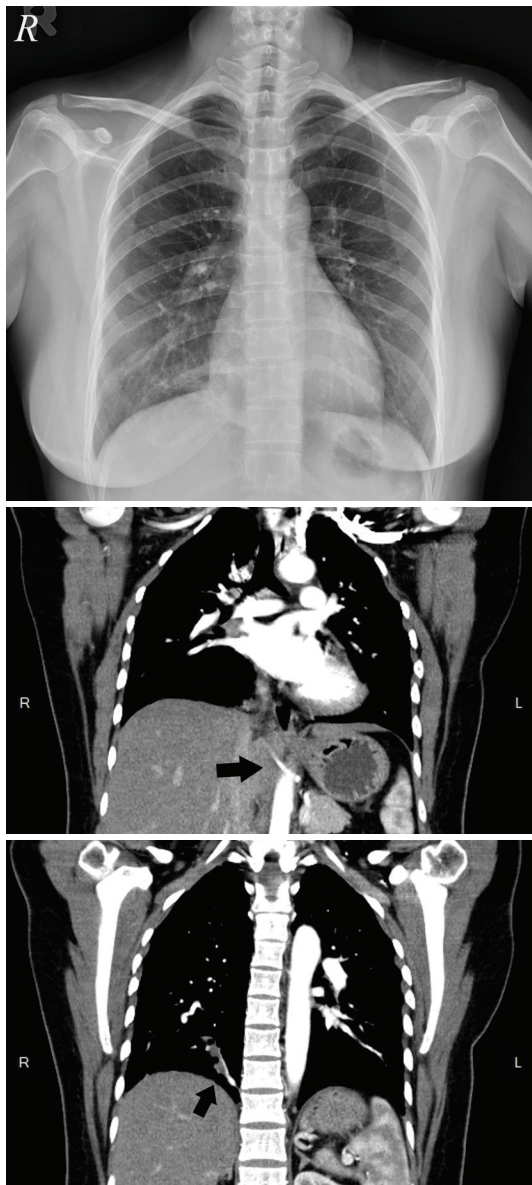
Upper: Chest plain film showed ill-defined patchy opacities in the right lower lung zone. Middle and lower: Computed tomography revealed small areas of irregular soft-tissue opacities with a feeding artery from the descending aorta and venous return to the pulmonary vein (black arrow)
